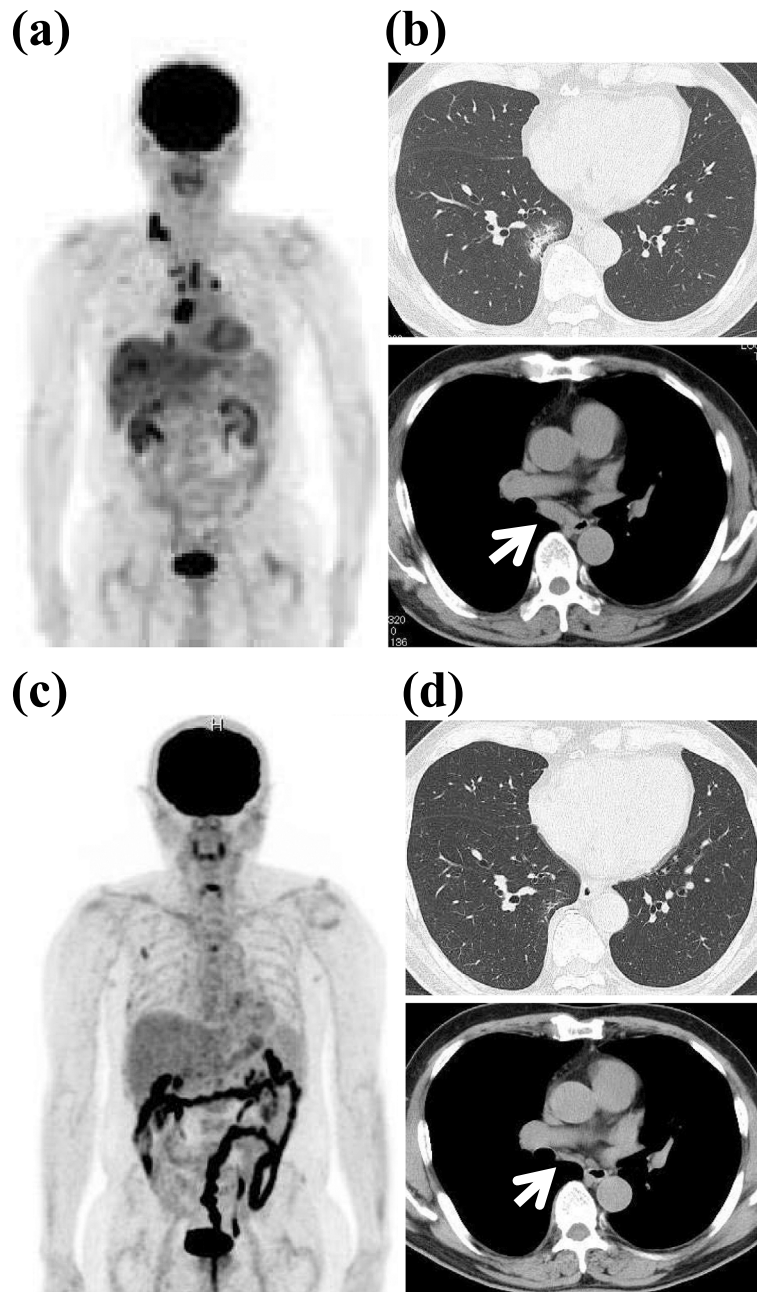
(a) FDG-PET/CT showed multifocal uptake lesions of supraclavicular and mediastinal lymphadenopathies, right lobe of the liver, right lower lobe of the lung, third right rib, fourth lumbar vertebra and prostate (supraclavicular lymph node: maximum standardized uptake value (mSUV) 9.85, supramediastinal lymph node: mSUV 4.73, paraaortic lymph node: mSUV 6.31, subcarinal lymph node: mSUV 12.31, right lobe of liver: mSUV 6.23, right lower field of the lung: mSUV 4.54, third right rib: mSUV 2.04, the fourth lumbar vertebra: mSUV 2.64, and prostate: mSUV 7.2). (b) Conventional CT showed infiltrations on S7 and subcarinal lymph node swelling (arrow). (c) Follow-up FDG-PET/CT one year after antibiotic treatment showed an improvement in the multifocal intensity lesions, confirming the efficiency of antituberculosis therapy. (d) Follow-up CT showed an improvement in the lung fields and subcarinal lymphadenopathy (arrow).
